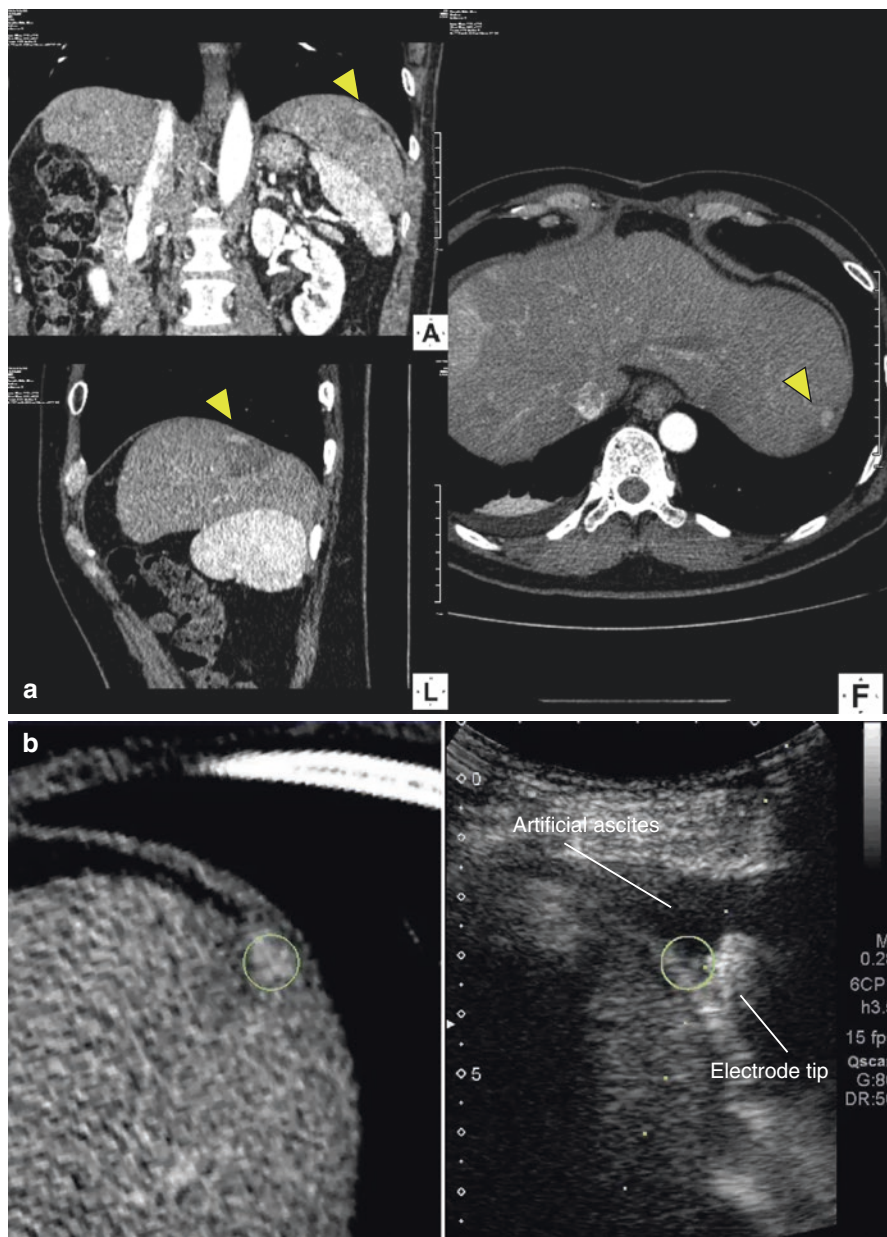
Representative case treated with radiofrequency ablation using the fusion imaging and artificial pleural effusion. (a) A small HCC nodule was detected in segment 2 under the right hepatic dome. (b) The left panel shows a virtual image reconstructed based on CT performed before ablation. The right panel shows a real ultrasonographic image during ablation. The circle indicates the target tumor. Left artificial pleural effusion was performed before ablation to get a clear view of the tumor. (c) Multiplanar reconstructed images before (left) and after (right) ablation. The tumor was completely ablated (arrow head)
